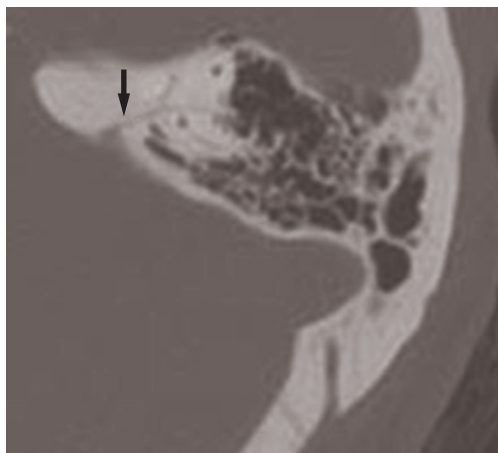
Axial CT scan. Slight dilation of the cochlear aqueduct (arrow).
